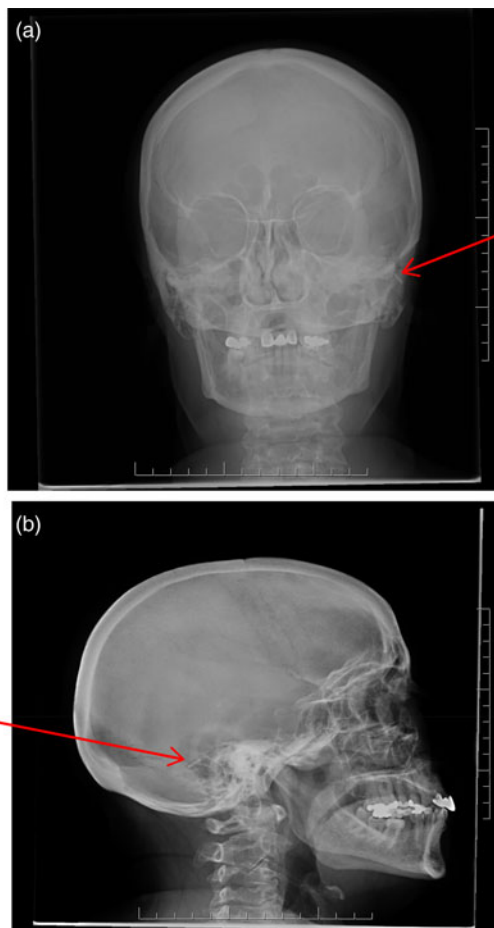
Post-operative anteroposterior (a) and lateral (b) skull X-rays confirm the clip position (arrows).
